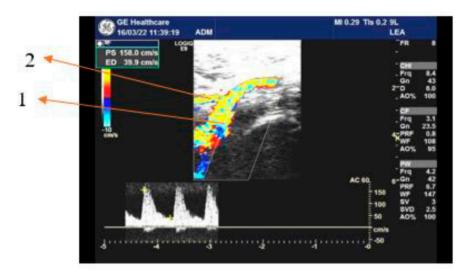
Left upper thigh anterior Doppler ultrasonography 1 – common femoral artery; 2 – superficial circumflex iliac artery
